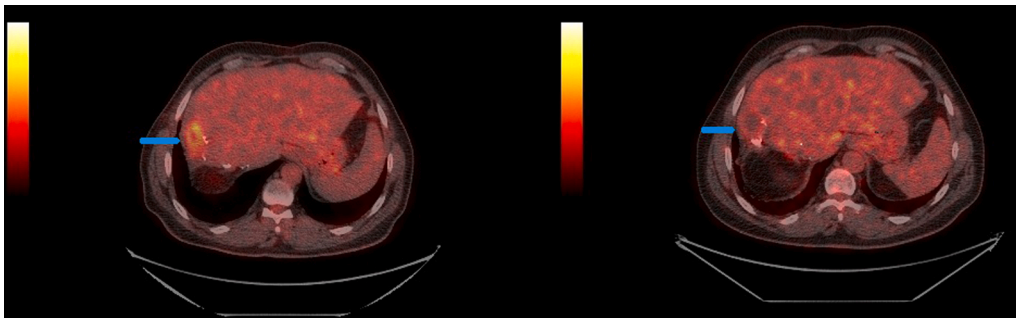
52 year old male patient with moderately differentiated adenocarcinoma of the colon with single liver metastasis status post colectomy and liver metastectomy and is on surveillance follow up for recurrence of disease with anatomic imaging showing indeterminate/equivocal/ suspicious findings at the site of the liver metastectomy. Image shows increased uptake in the liver on the post metastectomy scan at the site of prior metastectomy that was categorized as false positive due to postoperative inflammation given resolution on subsequent follow up FDG PET/CT.
